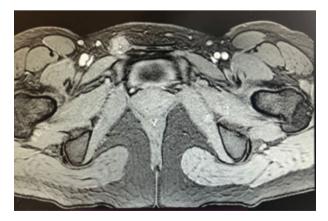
Axial T2-weighted MR image
